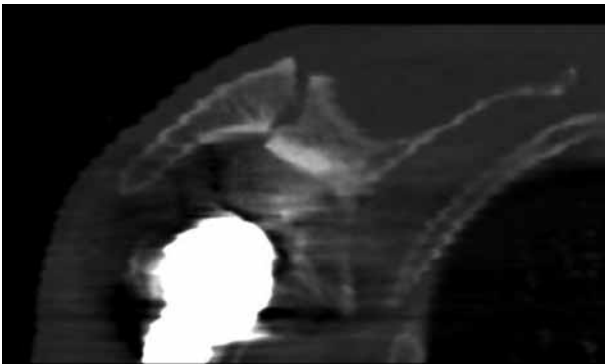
CT scan of the right shoulder
